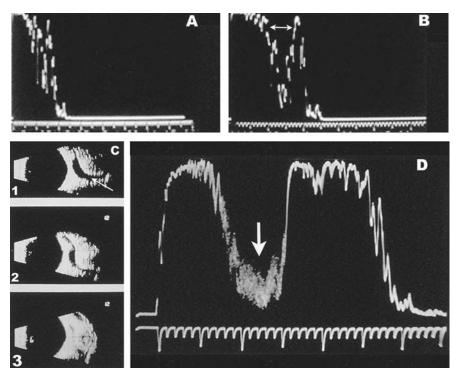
Vascular lesions: (A,B) orbital varices and (C,D) fast-draining carotid cavernous fistula. (A). Paraocular A scan shows low internal reflectivity with expansion of the lesion during Valsalva maneuver¹⁵ (arrow). (B) On B scan, orbital varices are linear, channeled lesions with echolucent internal structure.5 Sound attenuation is minimal. Color Doppler imaging shows nonpulsatile blood flow with apparent change in dimensions during respiration.¹⁶ (C) B scan shows a large, dilated superior ophthalmic vein (B1, arrow) which is typically meandering on sagittal topography.5,17 With dynamic echography, the size of the venous structure changes with the arterial pulsations from a near collapsed size (B3) to a widely dilated channel (B1). (D) A scan shows blurred, low reflective spikes from fast flowing blood (arrow). Sound attenuation is minimal, and color doppler imaging shows a pulsatile, arterial-type blood flow pattern in the superior ophthalmic vein.18
